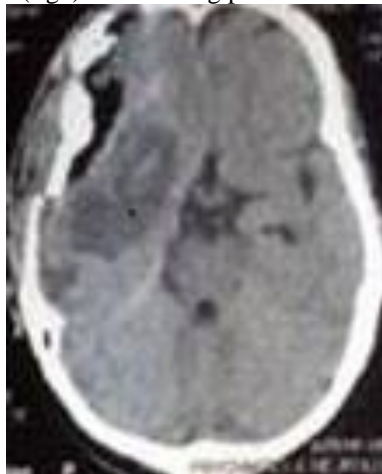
Postoperative CT brain axial cut showing near total surgical removal of preoperative embolized right sphenoid meningioma.
